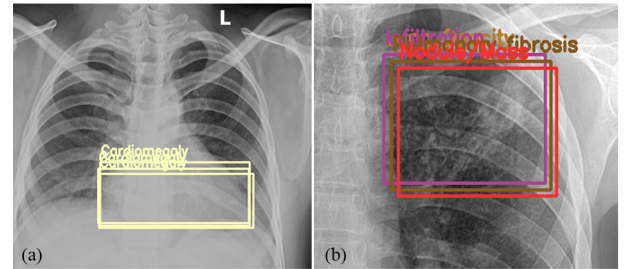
Due to the difficulty of the problem, the same region in an X-ray image could be annotated differently: (a) the same class of disease but different bounding boxes or (b) the different classes and different bounding boxes.
